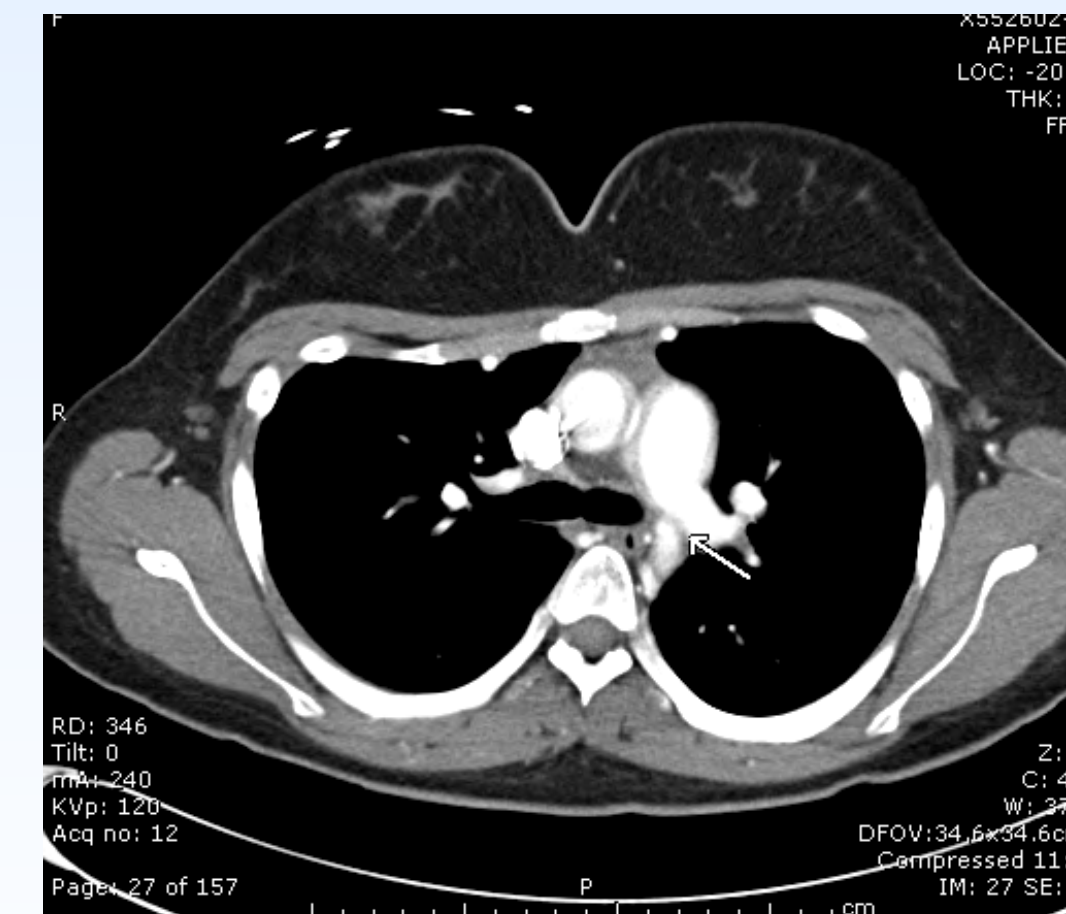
Axial view of CTA
